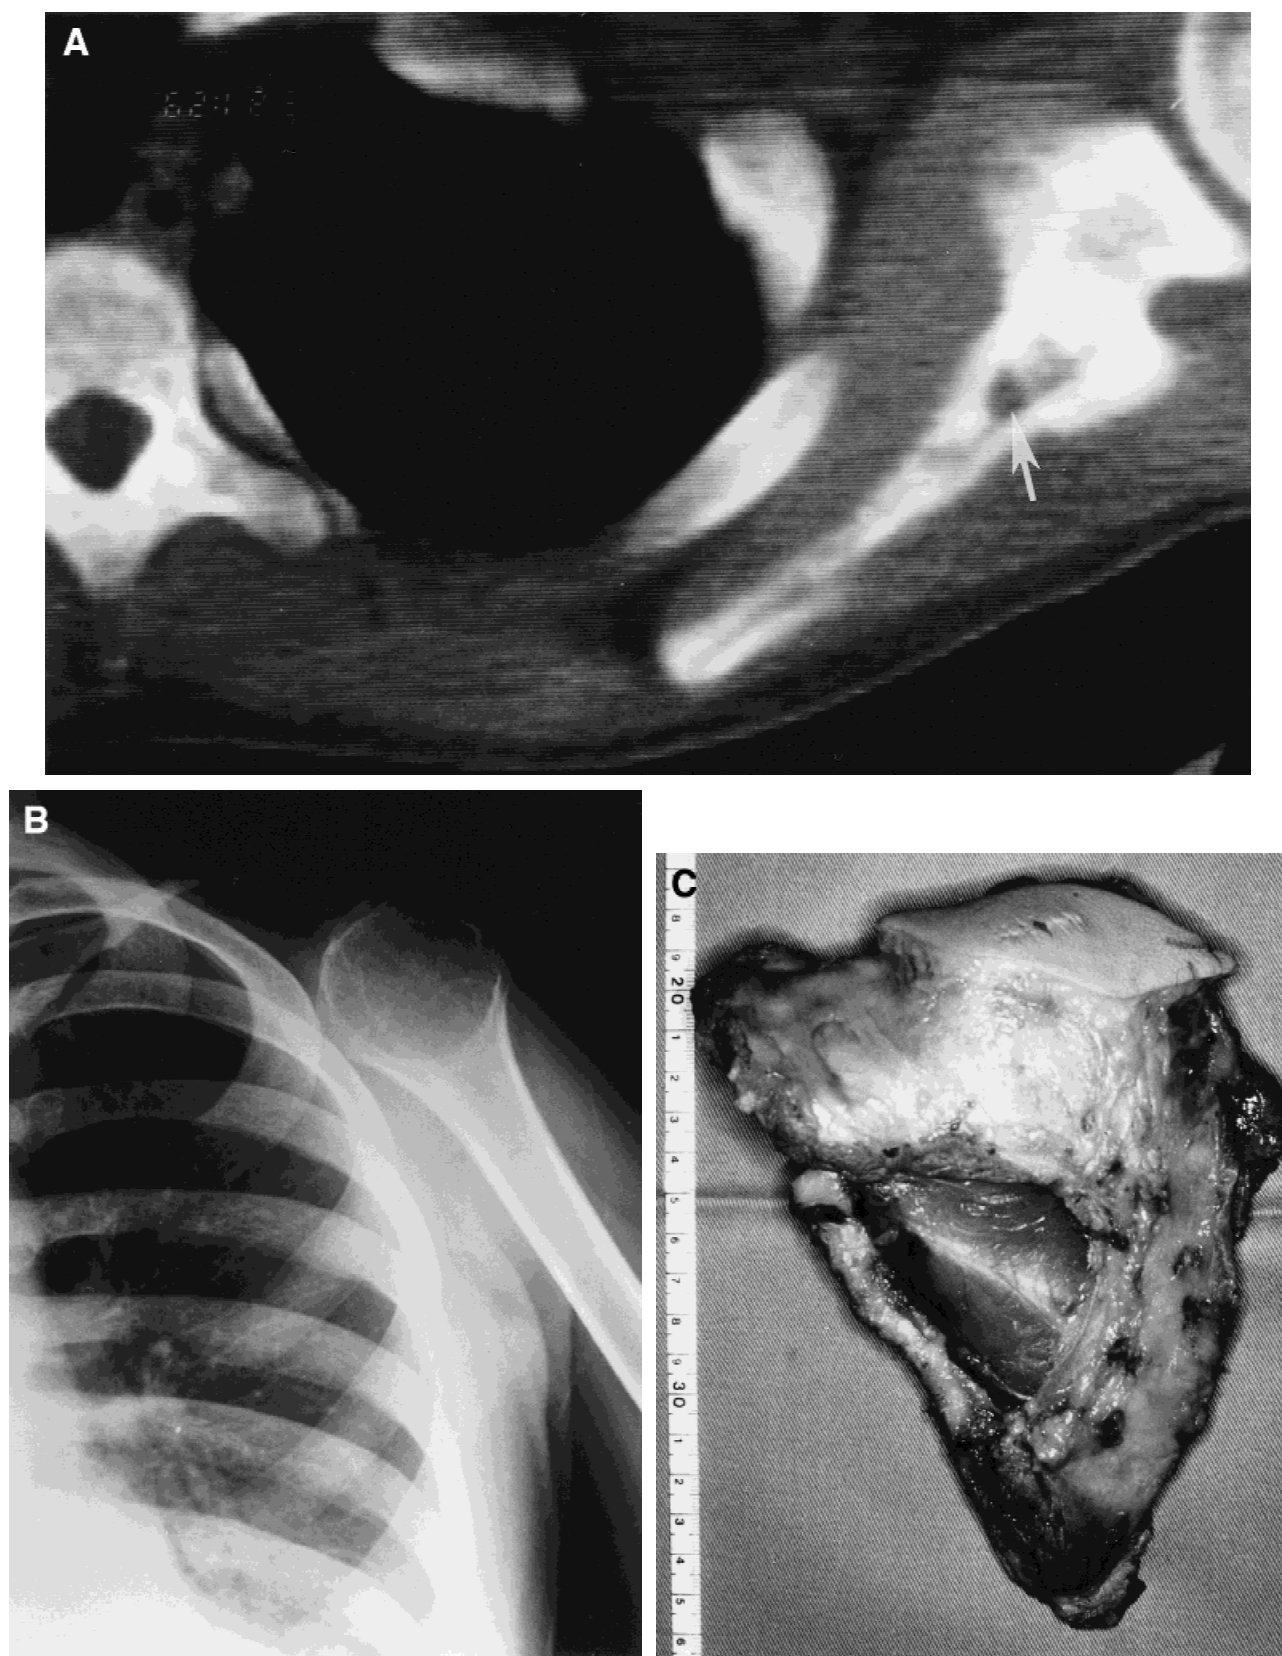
Case 1. A: Computed tomographic scan. Arrow = tumor invasion into scapula. B: Postoperative radiograph. C: Resected tumor from total scapulectomy.
